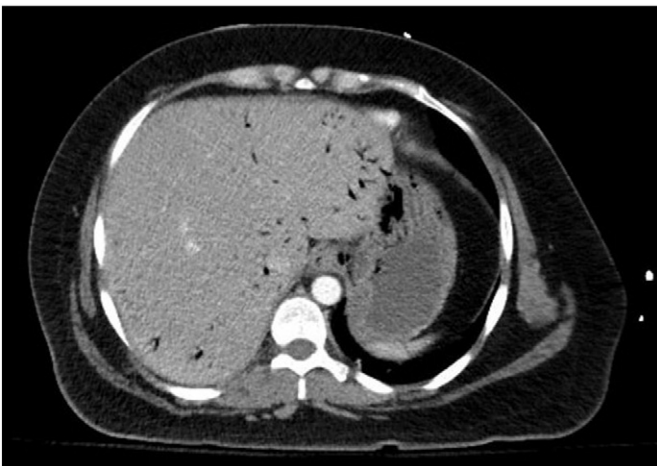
CT coronal image of pneumobilia in patient number 1.
